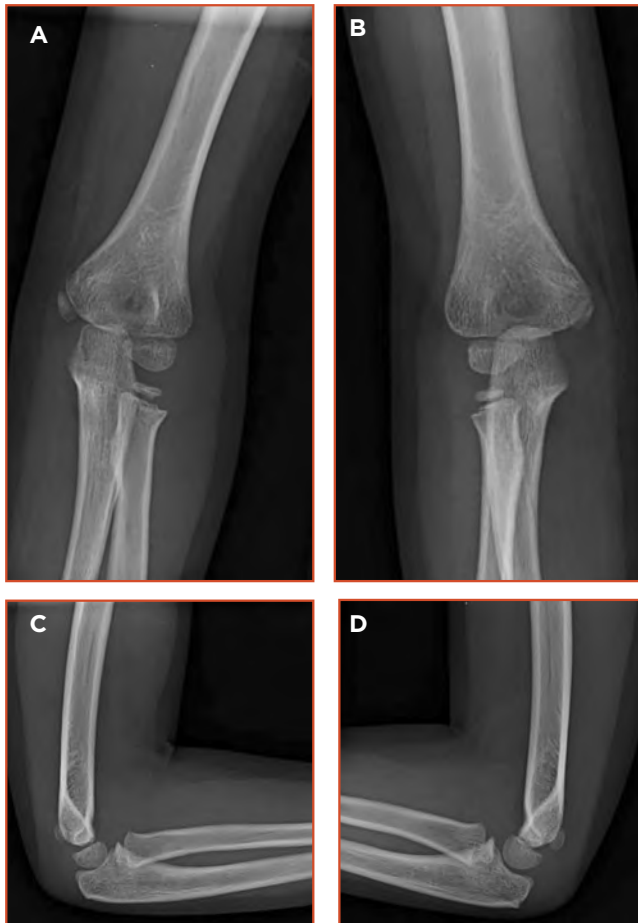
Radiographs of the left elbow at 4-year follow-up, showing remodeling and ossification of the radial head in A) anteroposterior view and B) lateral view. The uninjured right elbow is shown in C) anteroposterior view and D) lateral view.
